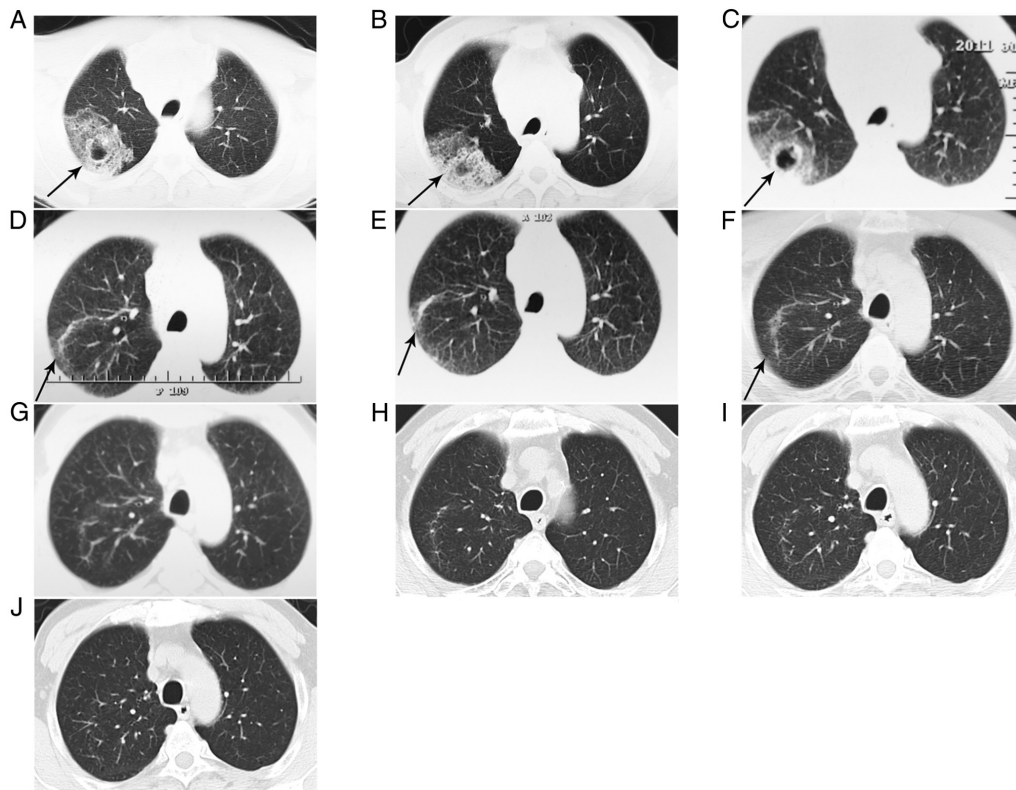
Changes of the lesion over time by chest computed tomography scan of the lung. (A) Before any treatment (2011-5-16). (B) After anti-inflammatory treatment (2011-6-3). (C) During therapy of docetaxel + carboplatin (2011-7-9). (D) During therapy of gemcitabine + cisplatin (2011-9-19). (E) During therapy of gemcitabine + cisplatin (2011-11-30). (F) After therapy of gemcitabine + cisplatin + radiation (2012-10-8). (G) Review (2014-4-11). (H) Review (2016-8-18). (I) Review (2018-7-3). (J) Review (2020-2-10). Arrows indicate the lesion.
